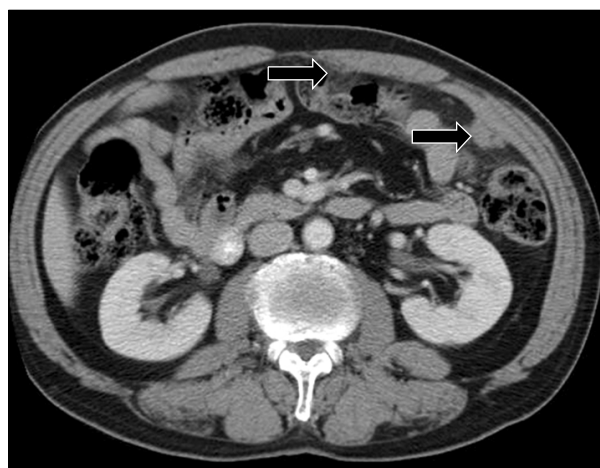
Follow up contrast-enhanced abdominal computed tomography (CT) showing markedly reduced omental masses (open arrows) as compared with the original, posttreatment CT.
